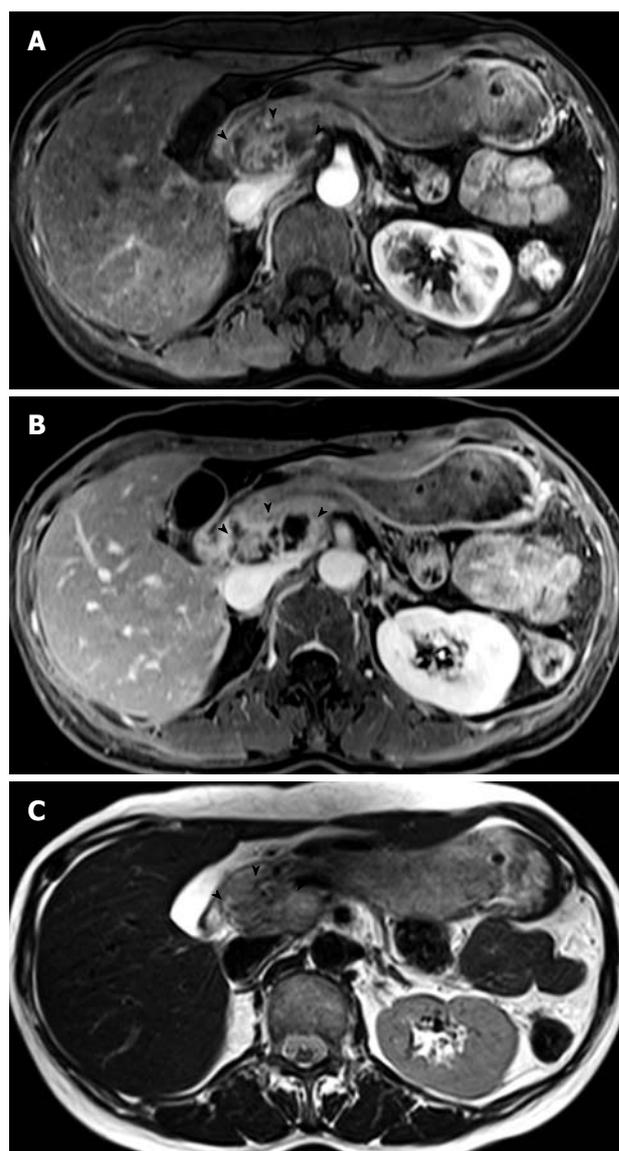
MRI of the pancreatic mass. A and B: Gadolinium-enhanced T-1 weighted image of the sharply delineated multiloculated mass in the pancreas head, with peripheral and central areas of enhancement; C: T-2 weighted image of the heterogeneous mass with increased and decreased signal intensities.
